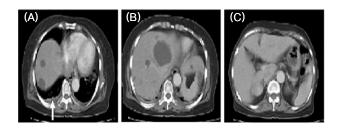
Abdomen and pelvic CT: Small amount pleural effusion (indicated by ? in A), multiple hepatic cysts (B) and post cholecysectomy state (C) were observed.
